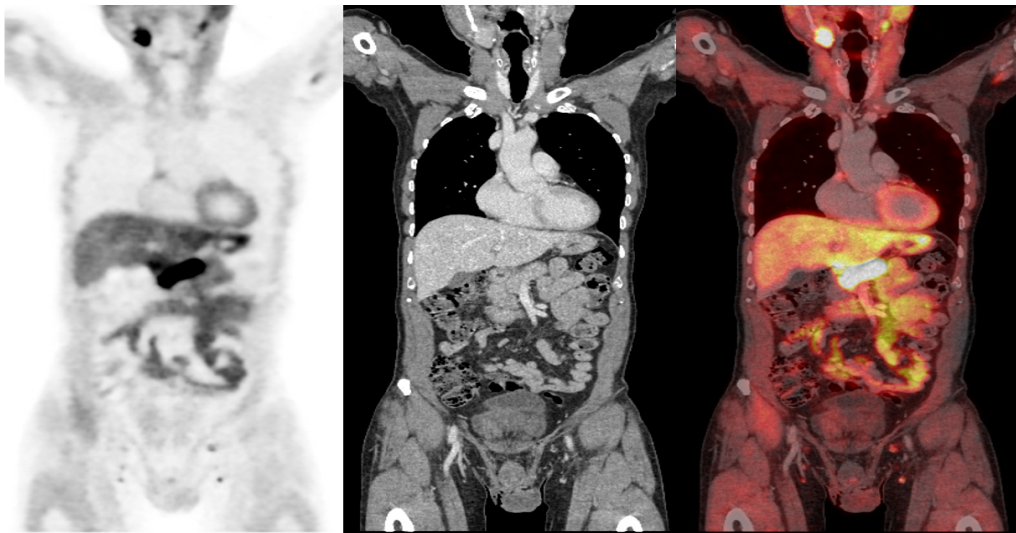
An example of PET-CT multimodal imaging. A PET image is displayed in the left panel with a probable tumorous region in darker pixel values. The corresponding CT image is displayed in the central panel. The right panel displays a fused PET-CT image with the likely tumorous region showing high metabolic activity [3].
